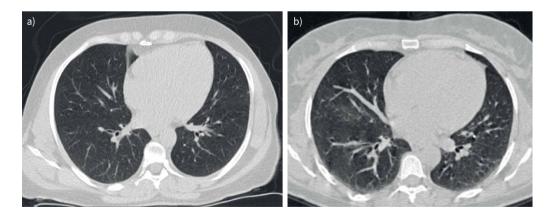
Representative computed tomography (CT) scan images from a participant with progression from high percentage of lung tissue characterised as CT lung injury to high percentage of lung tissue characterised as interstitial features. a) At age 39 years (year 15 examination), this participant had 33.9% of lung tissue characterised as CT lung injury (86th percentile for the cohort) and 1.1% of lung tissue characterised as interstitial features (76th percentile for the cohort). b) At age 49 years (year 25 examination), this participant had 55.9% of lung tissue characterised as CT lung injury (98th percentile for the cohort) and 26.6% of lung tissue characterised as interstitial features (99th percentile for the cohort).
